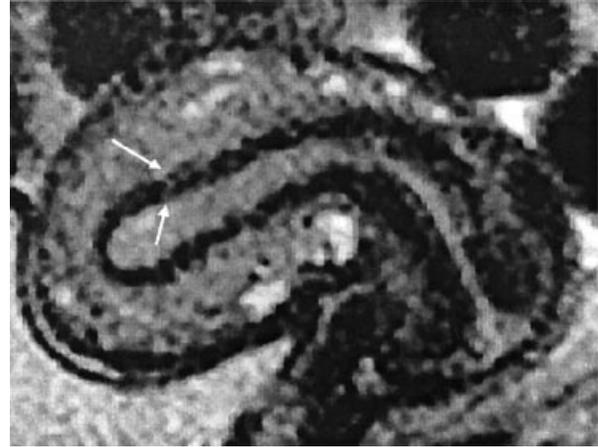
Magnetic resonance image of the uterus in the mid-sagittal plane. The arrows indicate the subendometrial myometrium or junctional zone.
